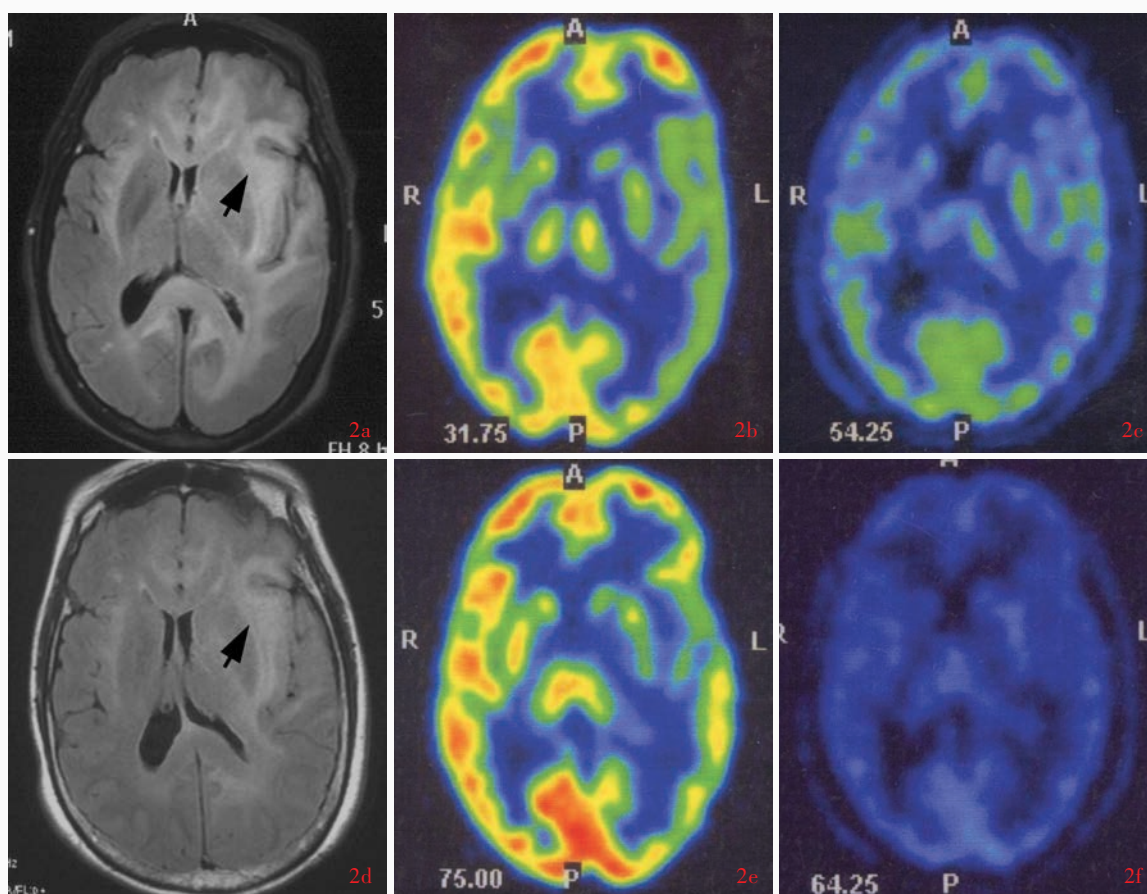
例2头部影像学检查所见 2a 横断面FLAIR成像显示,深部白质弥漫性高信号影(箭头所示) 2b ^{18}F -FDG PET显示,MRI所示病变同一位置无葡萄糖异常聚集 2c ^{11}C -MET PET显示,MRI所示病变同一位置无蛋氨酸异常聚集 2d 出院后6个月随访,横断面FLAIR成像显示,病变高信号减轻(箭头所示) 2e ^{18}F -FDG PET未见葡萄糖异常聚集 2f ^{11}C -MET PET未见蛋氨酸异常聚集
